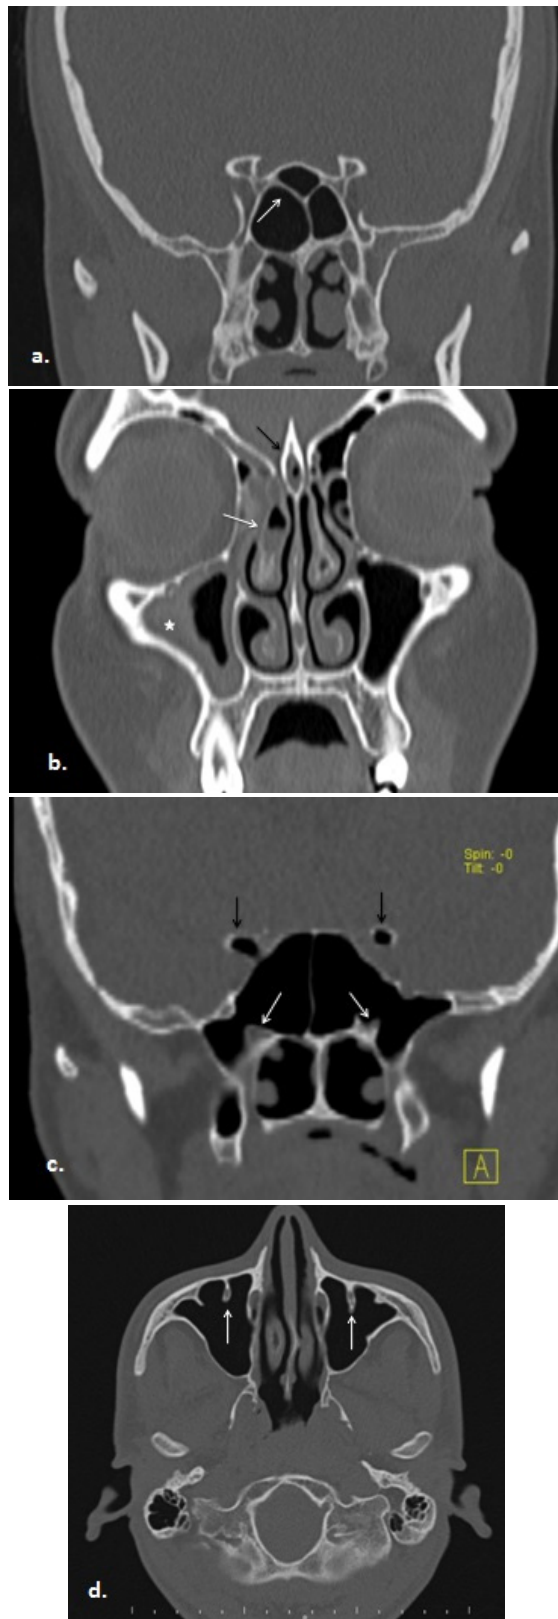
Coronal (a-c) and axial (d) CT images show different sinonasal anatomic variations. a: Onodi cell (arrow); b: Mucosal thickening within the pneumatized crista galli (black arrow) and right maxillary sinus (star) and fluid within right concha bullosa (white arrow); c: Bilateral anterior clinoid process pneumatization (black arrows) and bilateral vidian canal protrusion into the sphenoid sinus (white arrows); d: Bilateral maxillary nerve protrusion into the maxillary sinus (arrows).
